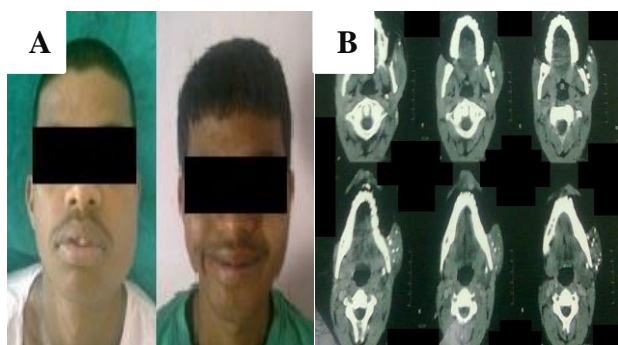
A & B: left cheek high flow vascular malformation involving masseter muscle (pre & post-operative image, MRI).
